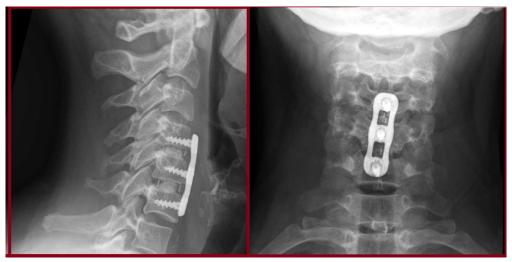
AP (right) and lateral (left) radiographs showing a plate and screws holding a cervical anterior cervical discectomy and fusion. (Case courtesy of Assoc Prof Craig Hacking, Radiopaedia.org, rID: 38120)
